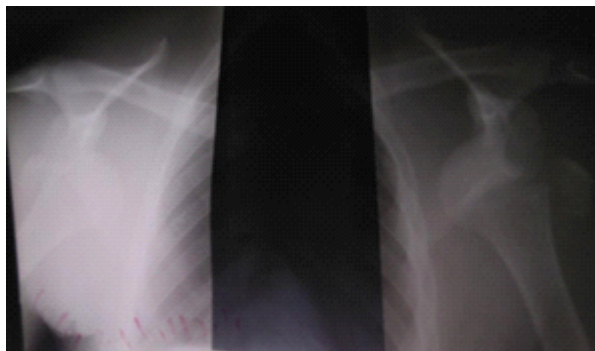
The radiograph of first case of bilateral anterior shoulder dislocation with bilateral greater tuberosity fractures.
